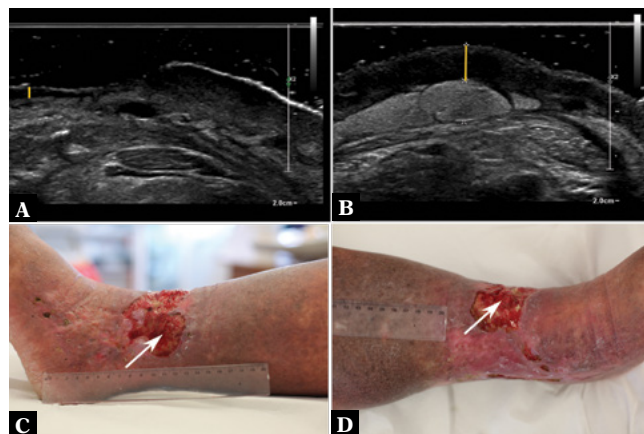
Example measurement of granulation tissue thickness. A. Ultrasound examination of the ulcer before laser therapy with granulation tissue thickness measurement. B. Ultrasound examination of the ulcer during laser therapy with an evident increase in the amount of granulation tissue and its measurement. C. Photographic image before laser therapy (the arrow marks the granulation tissue). D. Photographic image during laser therapy (the arrow marks the granulation tissue)
